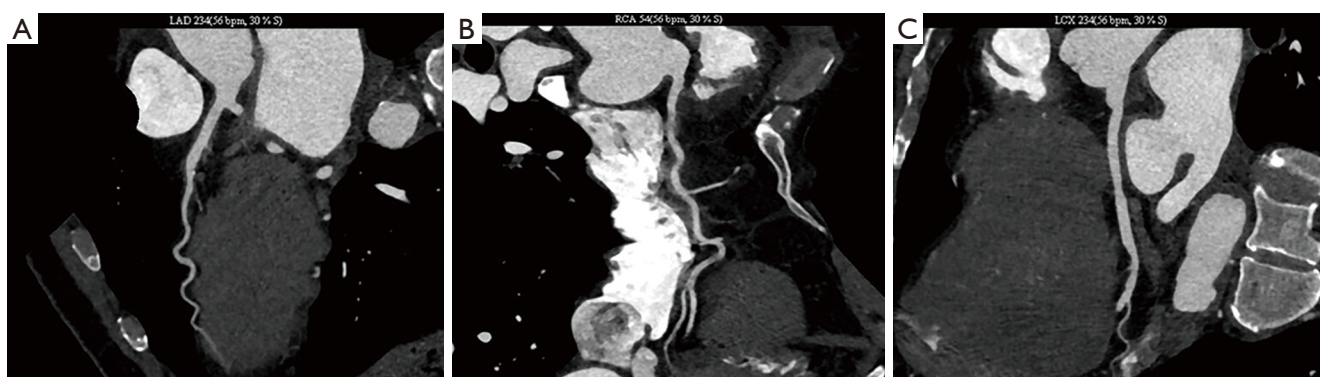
CT scan image of myocardium. (A) Moderate stenosis in the middle of the left anterior descending branch; (B) moderate stenosis of right coronary artery; (C) mild stenosis of the left circumflex branch.
